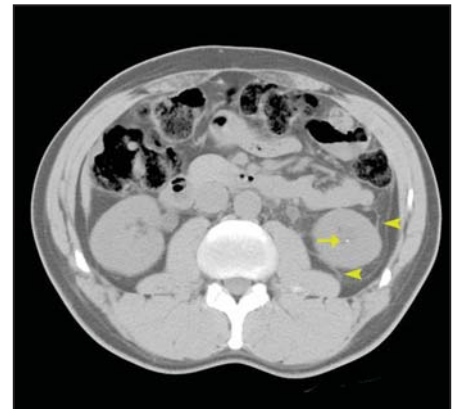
CT scan through lower renal poles.
